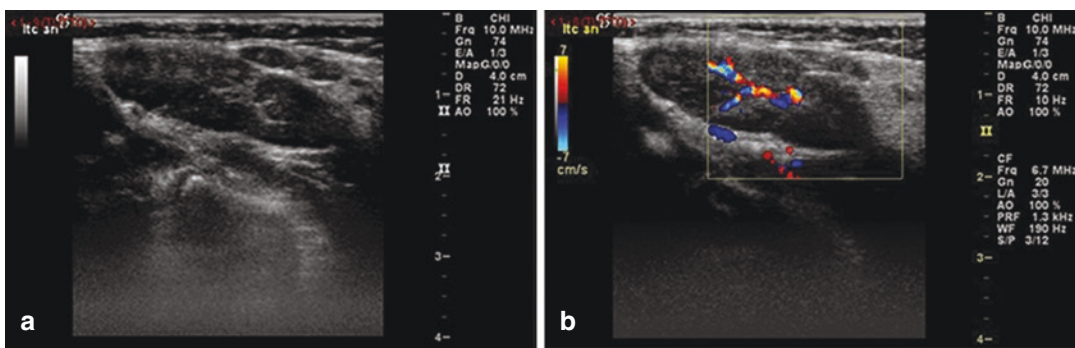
Ultrasound of reactive normal lymph node (a), oval-shaped, with hyperechoic hilum and regular Doppler vascular pattern (b)
